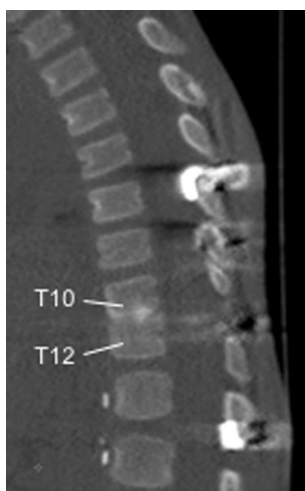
Postoperative sagittal CT reconstruction demonstrating fusion of the T10 and T12 bodies at 15 weeks, just before removal of instrumentation
